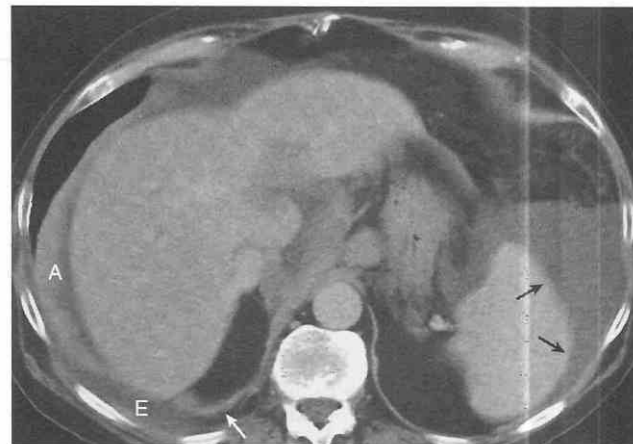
CT of "diaphragm" and "interface" signs. Ascites (A) is medial to the diaphragm (arrow), and a pleural effusion (E) is identified lateral to the diaphragm. A sharp interface can be seen between the ascites and the spleen (arrows).
